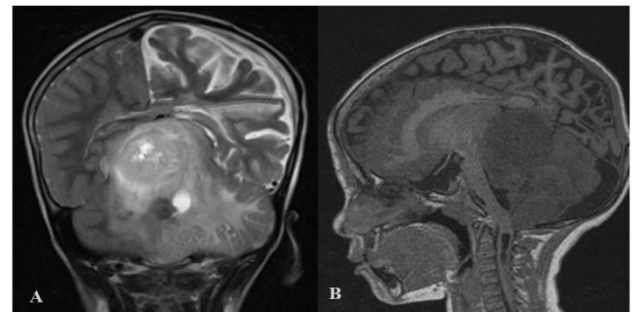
Known case of Neurofibromatosis type1 in a 6-year-old female patient presenting with recurrent seizures and s/p VP shunting. A) T2W coronal MR image and B) T1W sagittal MR image showing following findings-Bulky cerebellum and multiple ill-defined enhancing lesions with moderate perilesional edema and causing mass effect? gliomas. Left cerebral hemisphere appearing relatively bulky with prominence of cortical sulci and gliosis in the left occipital lobe. Prominent cisterna magna.
